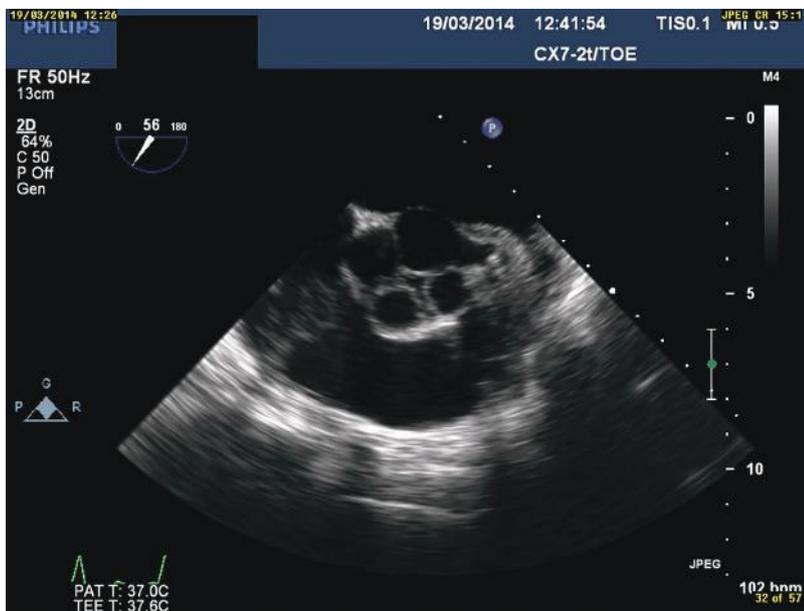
Image of an upper position transesophageal echocardiography view showing a quadricuspid aortic valve in a 64-year-old woman with a history of lobectomy for a bronchial adenoma and dyspnea on exertion (Case 2).
